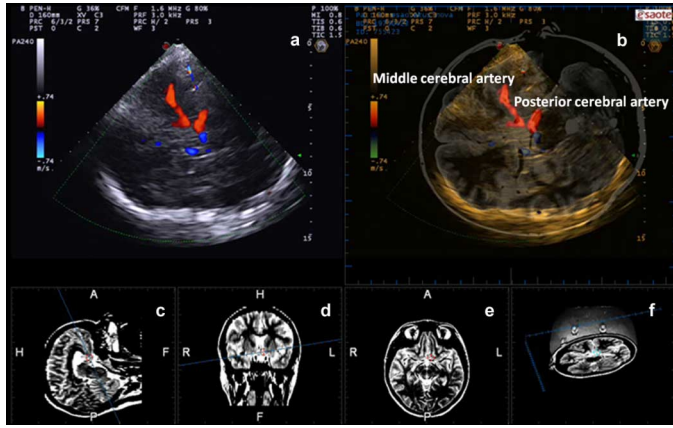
(a) Middle and posterior cerebral arteries visualization in the US and (b) their fusion to MRI volume, as internal anatomical confirmation of the correct coregistration between US and MRI. The insonation plane orientation is visualized on (c) sagittal, (d) coronal and (e) axial views; (f) cut MRI rendering corresponding to the current US insonation plane. The matching of the middle and posterior cerebral arteries was obtained after a registration with facial landmarks, followed by a 0.3 cm lateral manual shift of the US in the axial plane and 0.4 cm in the cranial direction.
